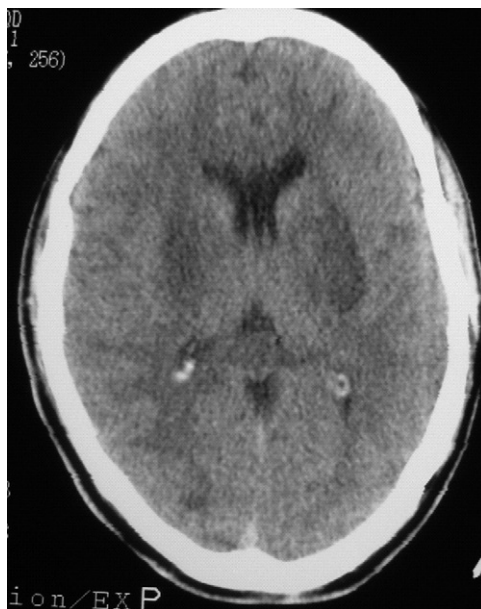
Brain computed tomographic scan without contrast showing bilateral putamen necrosis. Used with permission of Mohsen Esfandbod, MD, Department of Emergency Medicine, Imam Khomeini Hospital, Tehran University of Medical Science, Tehran, Iran.
